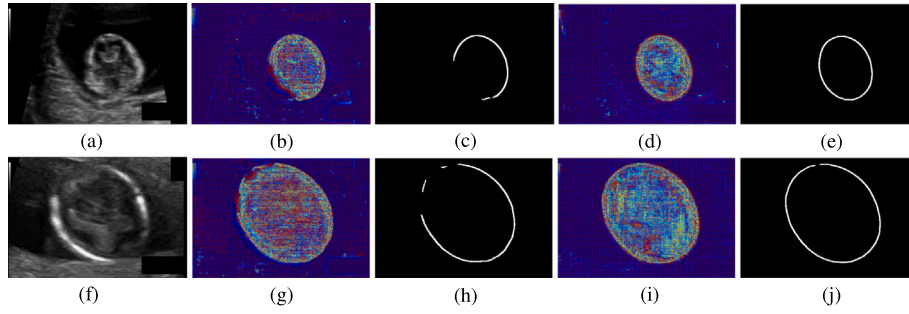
Comparison between with and without feature fusion module. (a) is an ultrasound image with a blurring boundary. (b) is the output feature without the feature fusion module in the model. (c) is the detected head boundary without the feature fusion module. (d) is the output feature with the feature fusion module in the model. (e) is the detected head boundary with the feature fusion module. (f) is an ultrasound image with boundary missing. (g) is the output feature without the feature fusion module in the model. (h) is the detected head boundary without the feature fusion module. (i) is the output feature with the feature fusion module in the model. (j) is the detected head boundary with the feature fusion module. It can be seen that more details about head boundary can be found by the context information from the segmentation branch.
